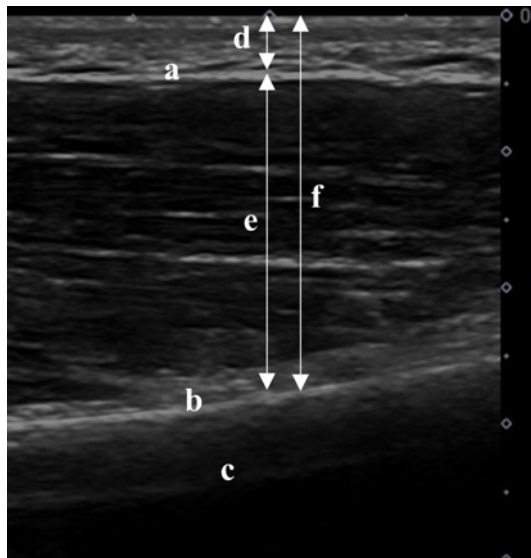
Ultrasound image at B-Extension when using the Flat condition.
